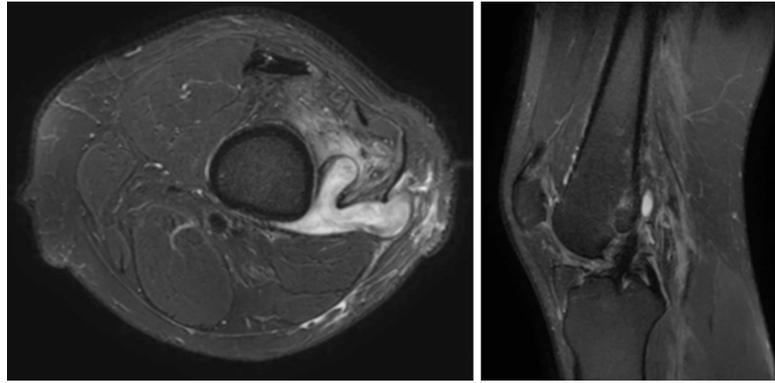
Magnetic resonance imaging knee showing a fistulous communication of a complex Y-shaped abscess in the lateral aspect of the distal thigh extending towards the femoral tunnel of the anterior cruciate ligament reconstruction.
